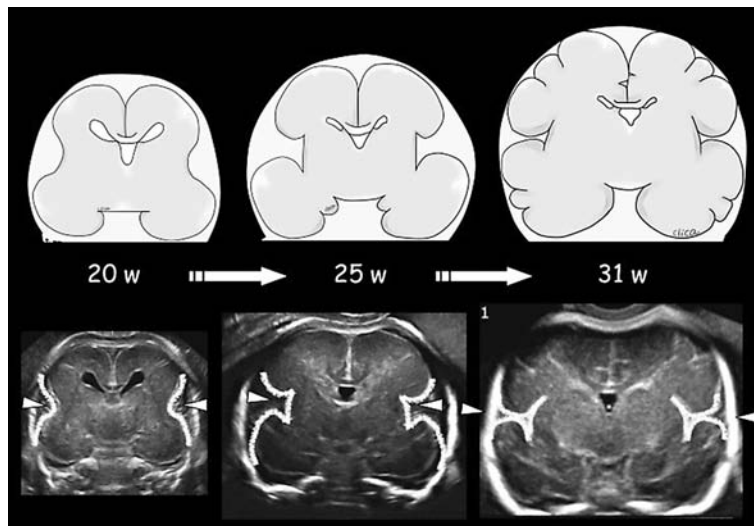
Changing appearance of Sylvian fissure in the anterior coronal section by transvaginal sonography
